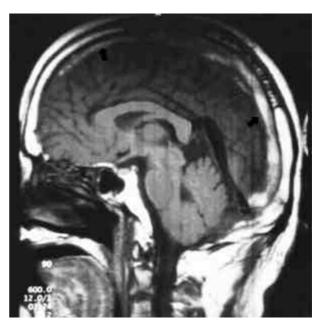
Sagittal precontrast T-1 weighted MRI shows the clot within the SSS (arrow) and a thrombosed cortical vein (open arrow).
